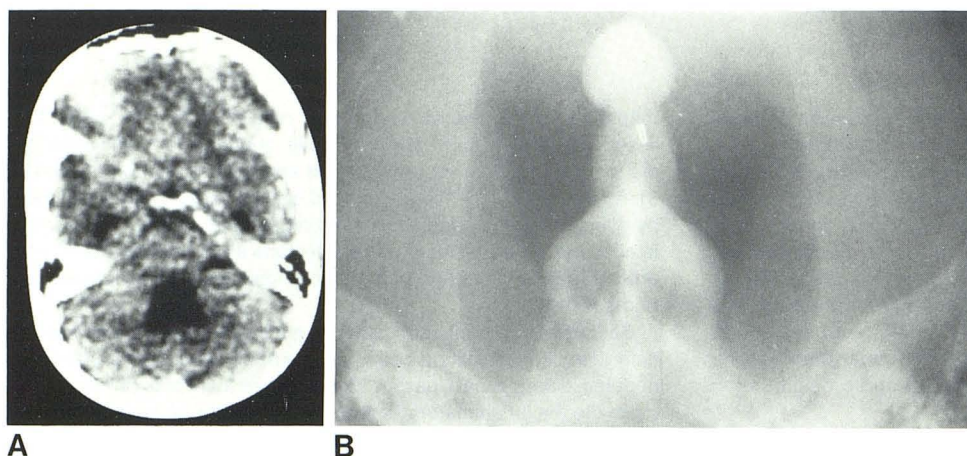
40-year-old black man with headache and sudden loss of consciousness. CSF pleocytosis. A, Postcontrast CT. Hydrocephalus and large fourth ventricle without demonstrable cysts. B, Dimer ventriculogram shows cysts as filling defects in fourth ventricle.
